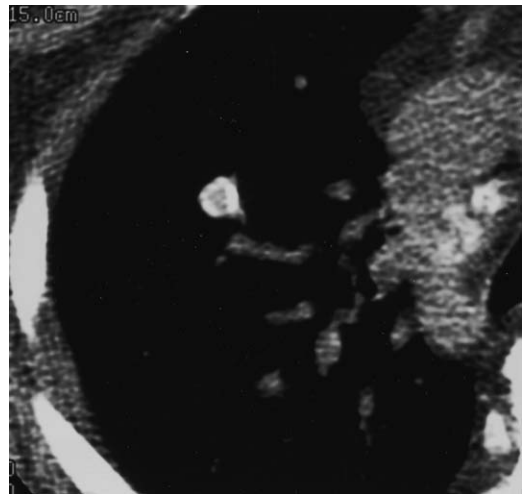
Thin-section CT of the chest with soft tissue window shows a more lamellar-type calcification of a pulmonary nodule. This was a benign calcified granuloma. Note the associated calcified mediastinal nodes.
